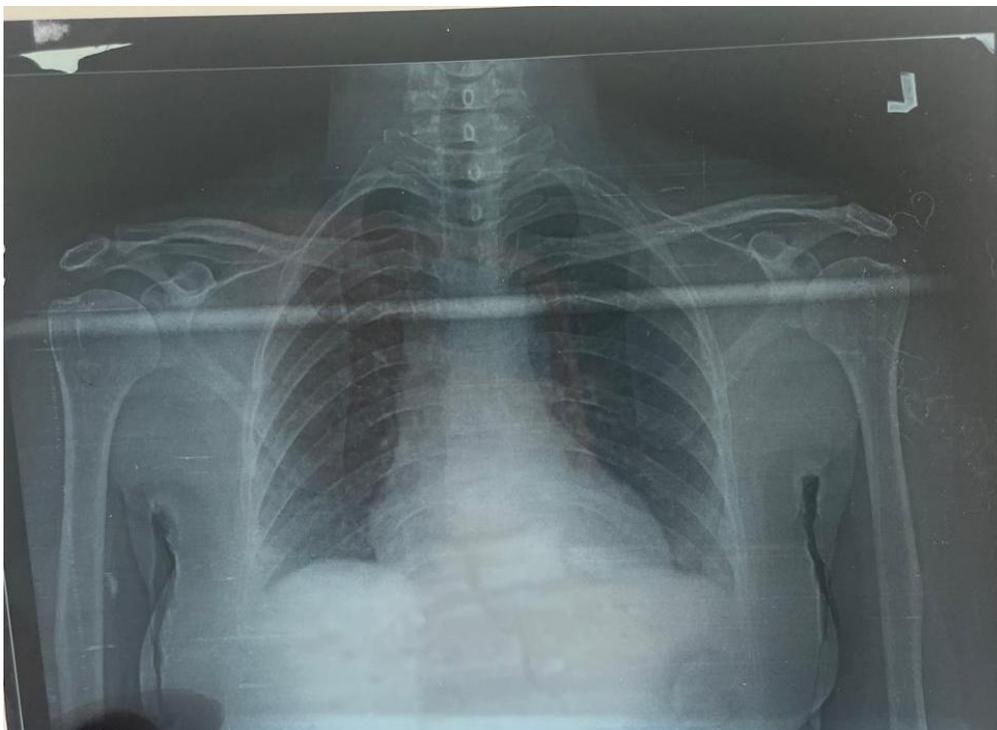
(d): X-ray of long bones showing thinning of cortex
